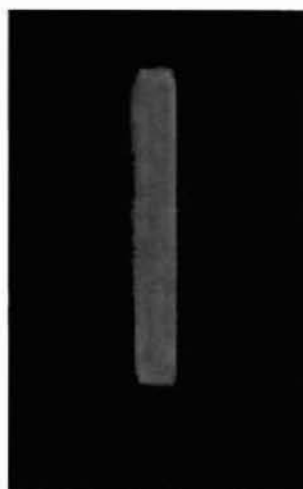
X-ray photograph of CMC/PVA microspheres containing barium sulphate (filled in polyethylene tube)
